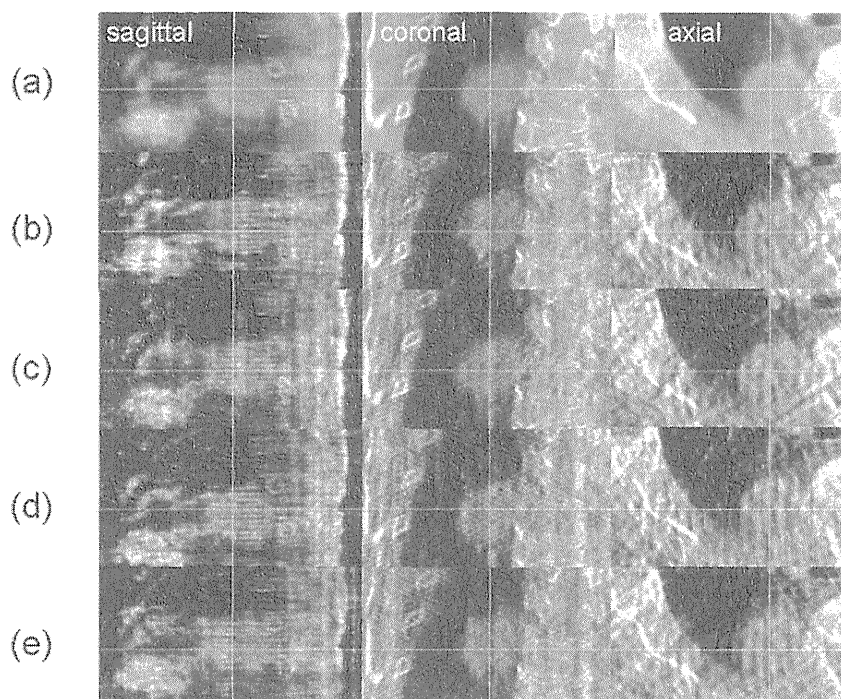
kV 4D CBCT images of a lung tumor patient during VMAT delivery in four different respiratory phases: (a) reference 3D CBCT, (b) maximum exhalation, (c) mid inhalation, (d) maximum inhalation, and (e) mid exhalation. The cross lines indicate the isocenter. 2D image data were acquired during 2 minute, half gantry rotation with 652 projections. The 4D image indicates that the tumor size is approximately 35 mm in the cranio-caudal direction, while the tumor size is detected as approximately 42 mm with 3D CBCT. In addition, it is found from 4D CBCT that the tumor movement amplitude is approximately 9 mm in the cranio-caudal direction.
